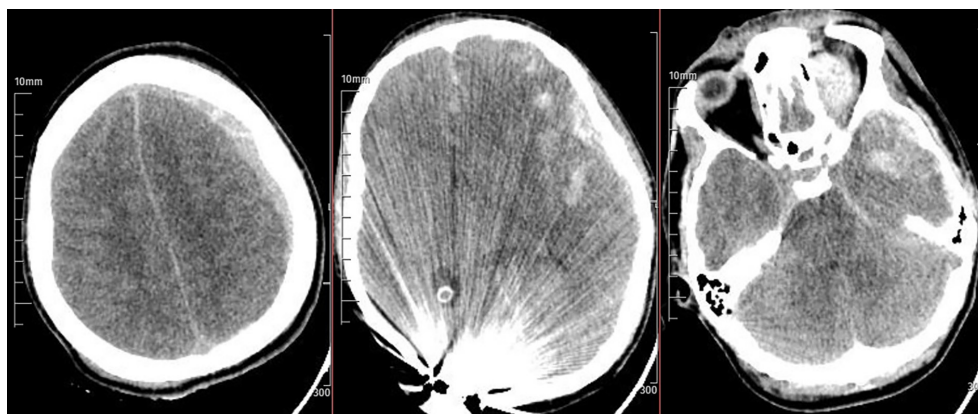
Severe head trauma patients preoperative CT images
